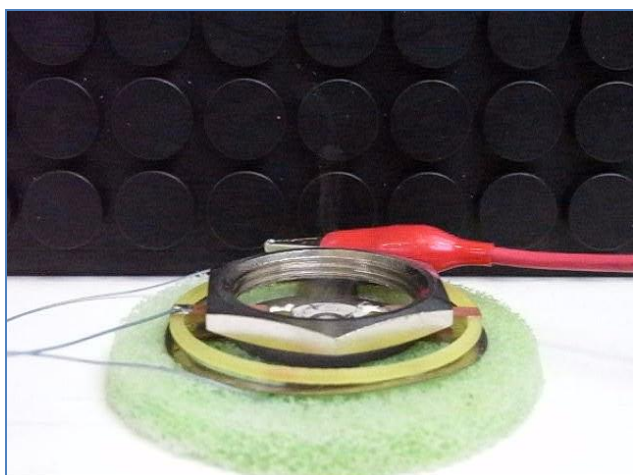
Developed ultrasonic atomisation unit prototype under testing using off-shelf piezoelectric drive and HME materials
